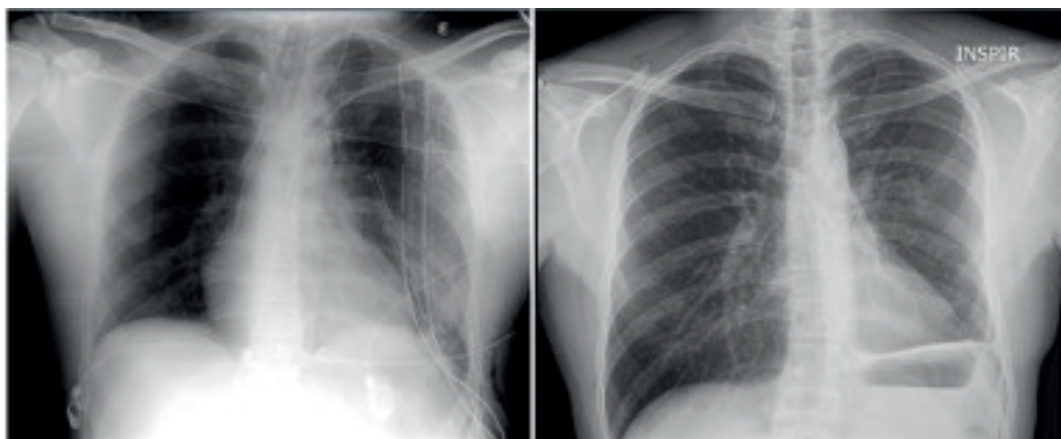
(A) Chest radiograph at 24 hours post-pleurectomy/decortication surgery. (B) Chest radiograph at 4 months post-pleurectomy/decortication surgery.
